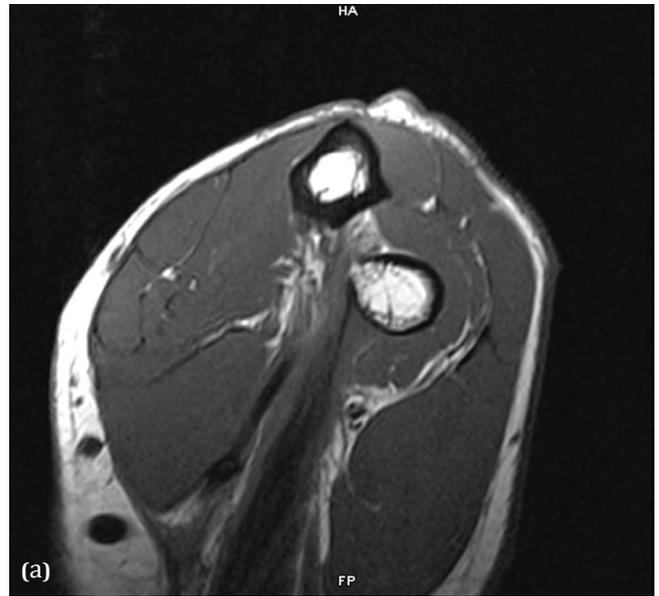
Flexed Abducted Supinated View MRI T1.
